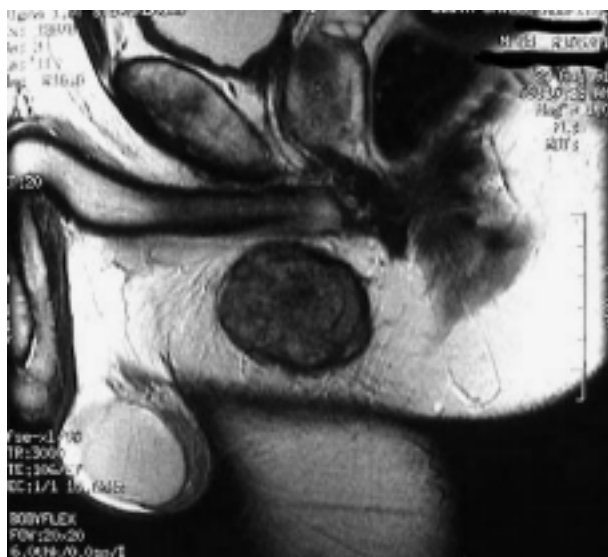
T2 weighted sagittal pelvic MRI scan showing the well-circumscribed lesion in the perineum.
